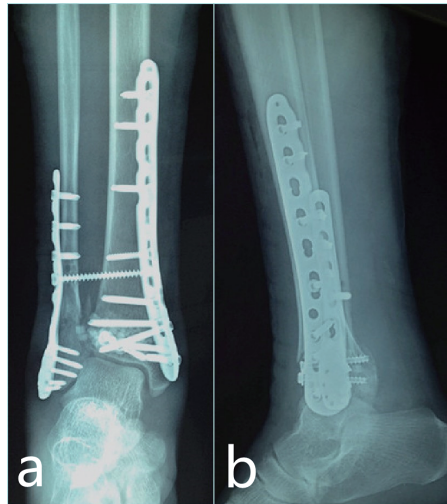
Radiographs taken the day following ORIF (open reduction and internal fixation) reveal near-anatomic repair of the articular surface as well as corrected limb alignment
